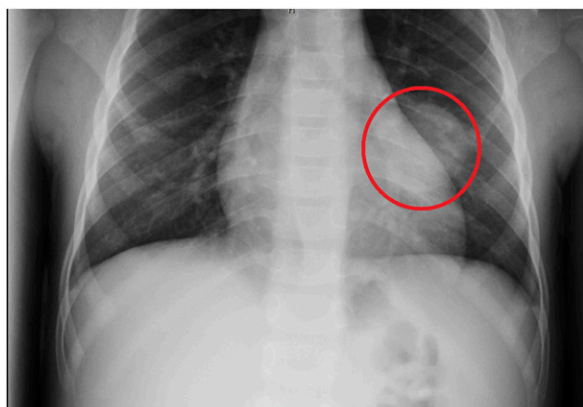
Chest radiograph depicting the presence of a focal rounded opacity overlying the left mid-lung measuring approximately 4.5 cm (red circle).
